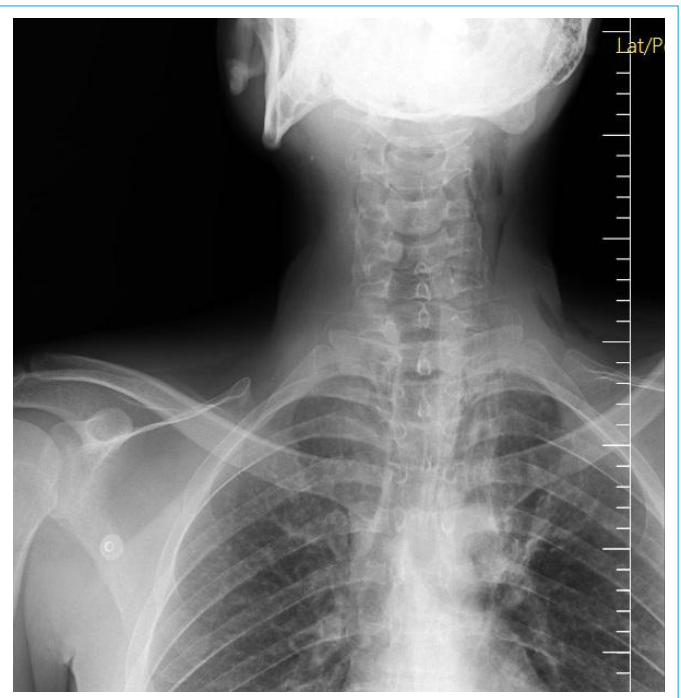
Subcutaneous emphysema is observed in cervical back-front radiography.
